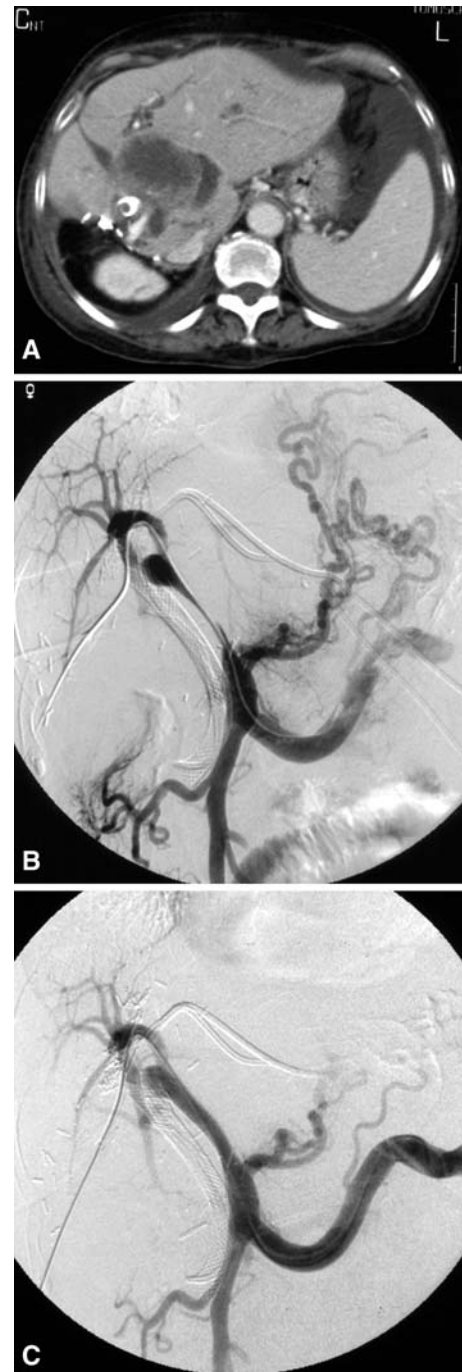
A 77-year-old woman with liver metastasis from colonic adenocarcinoma leading to biliary malignant obstruction treated via the retrograde endoscopic route 3 months ago (patient 7). Current esophageal varices bleeding and ascites in relation to a malignant venous portal stenosis. A Contrast-enhanced computed tomography showing liver hilar metastasis inducing recurrent intrahepatic biliary dilation, stenosis of the main PV, and ascites. B Initial superior mesenteric venography showing the stenosis of the main PV extending to the left PV and esophageal varices. C Repeated superior mesenteric venography after portal venous stent placement with no residual filling of periesophageal venous collaterals. Ascites had not decreased by the time of the patient's death 14 days later
